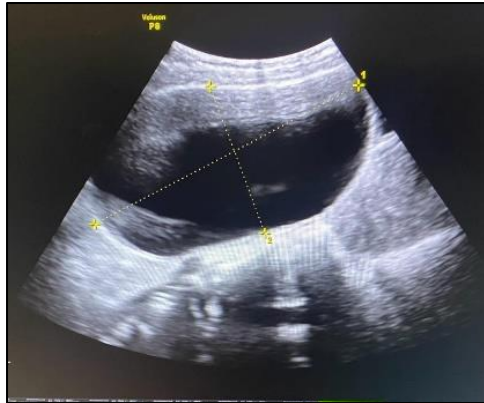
Ultrasound of the abdomen and pelvis showed right adnexal cyst of about 12x6.3 cm closely abutting the right ovary. Uterus showed minimal free fluid in cavity possibly suggestive of endometritis.
